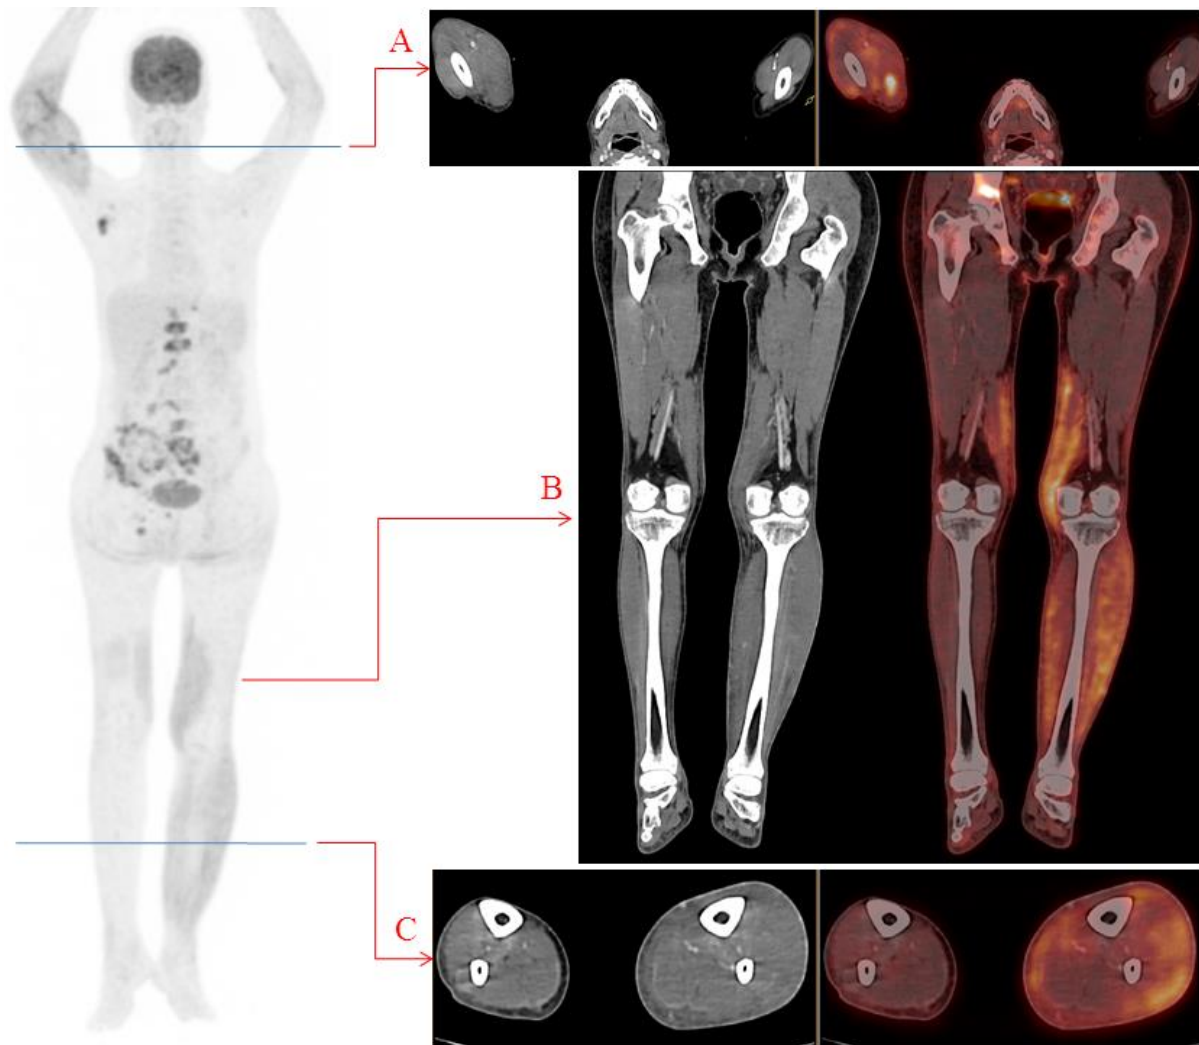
Maximum intensity projection (MIP) image of staging ^{18}F FDG PET scan A: axial section at the level of mid arm of CT and corresponding PET/CT shows metabolically active musculocutaneous lesion with enlarged muscles of left extremity without CT attention changes in muscles B and C: coronal and axial sections of CT and corresponding PET/CT show metabolically active bilateral semitendinosus, left leg muscles and overlying skin lesions without CT changes in enlarged affected muscles
